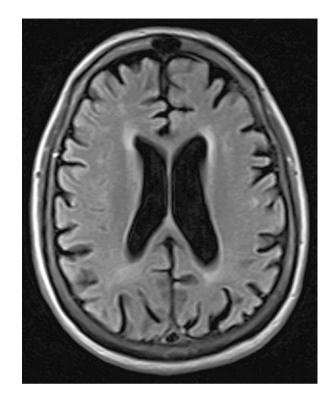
Axial cranial MRI, T1 sequence, showing a mild to moderate generalized atrophy with periventricular hyperintensities as well as small juxtacortical ones
